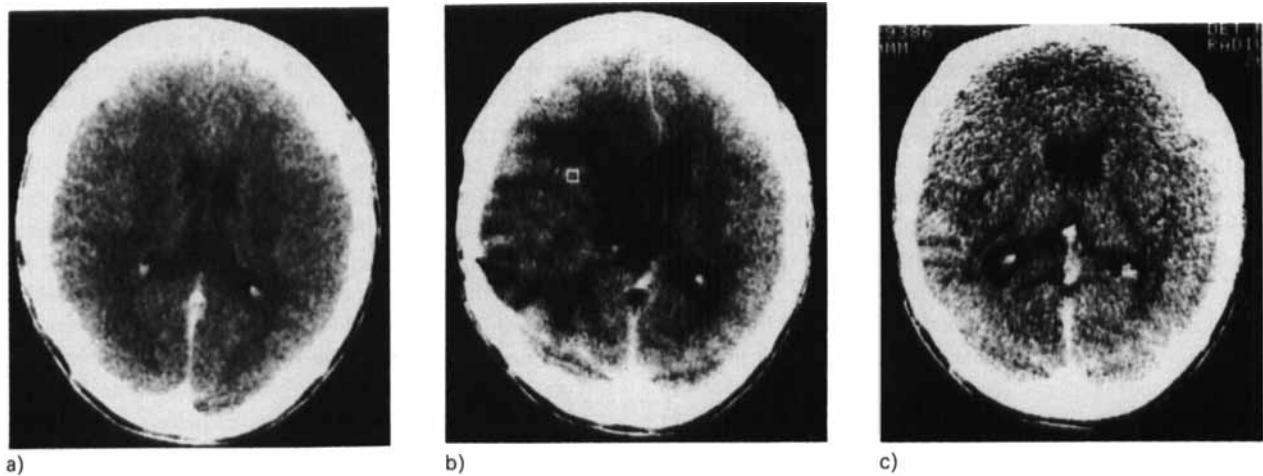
Case No. 2. a) CT before start of intraarterial carmustine. Postoperative changes after right-sided craniotomy. Slight degree of right sided expansion. b) CT 6 months after radiation treatment. Marked right-sided expansion with oedema and small area of enhancement. c) CT 12 months after irradiation. Normalization of earlier oedema and expansion.
